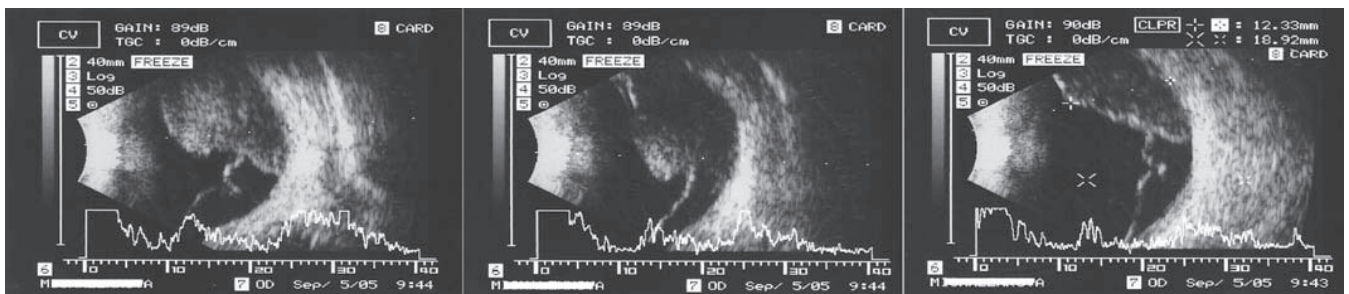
Ultrasound examination – Bscan: deposit of malignant melanoma of the choroidea with maximum elevation more than 12 mm, secondary amotio – condition before stereotactic radiosurgery in 2005
